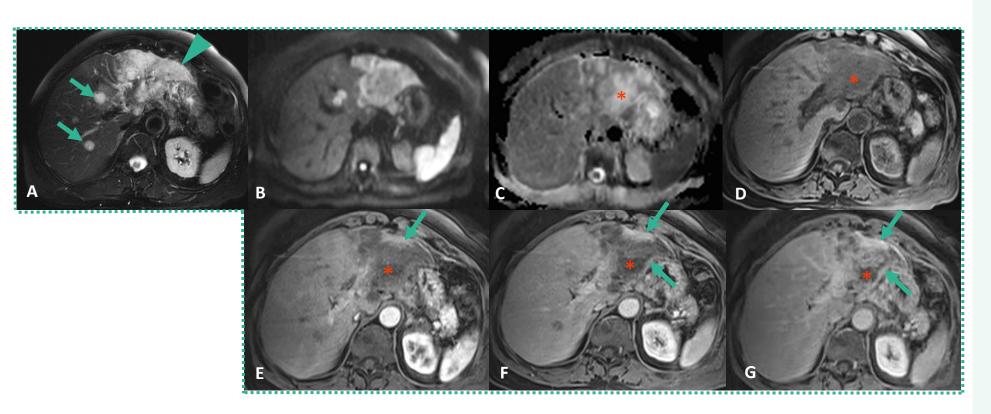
Contrast-enhanced MRI - Mass-forming type of hepatic cholangiocarcinoma.
